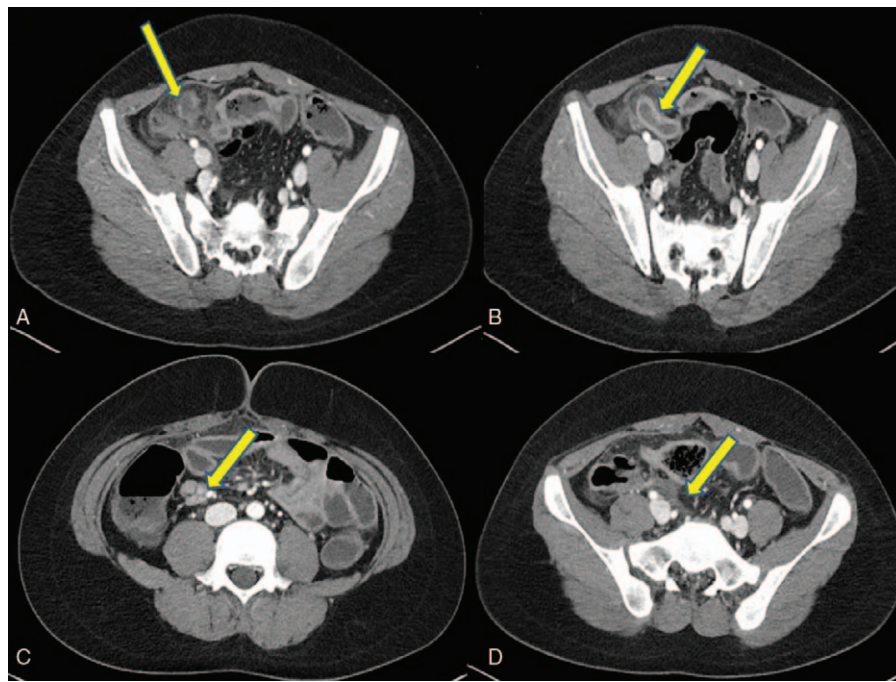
Initial computed tomography finding: (A, B) acute appendicitis, (C) enlarged lymph node at ileocolic area, and (D) fluid collection at ileocolic area.
